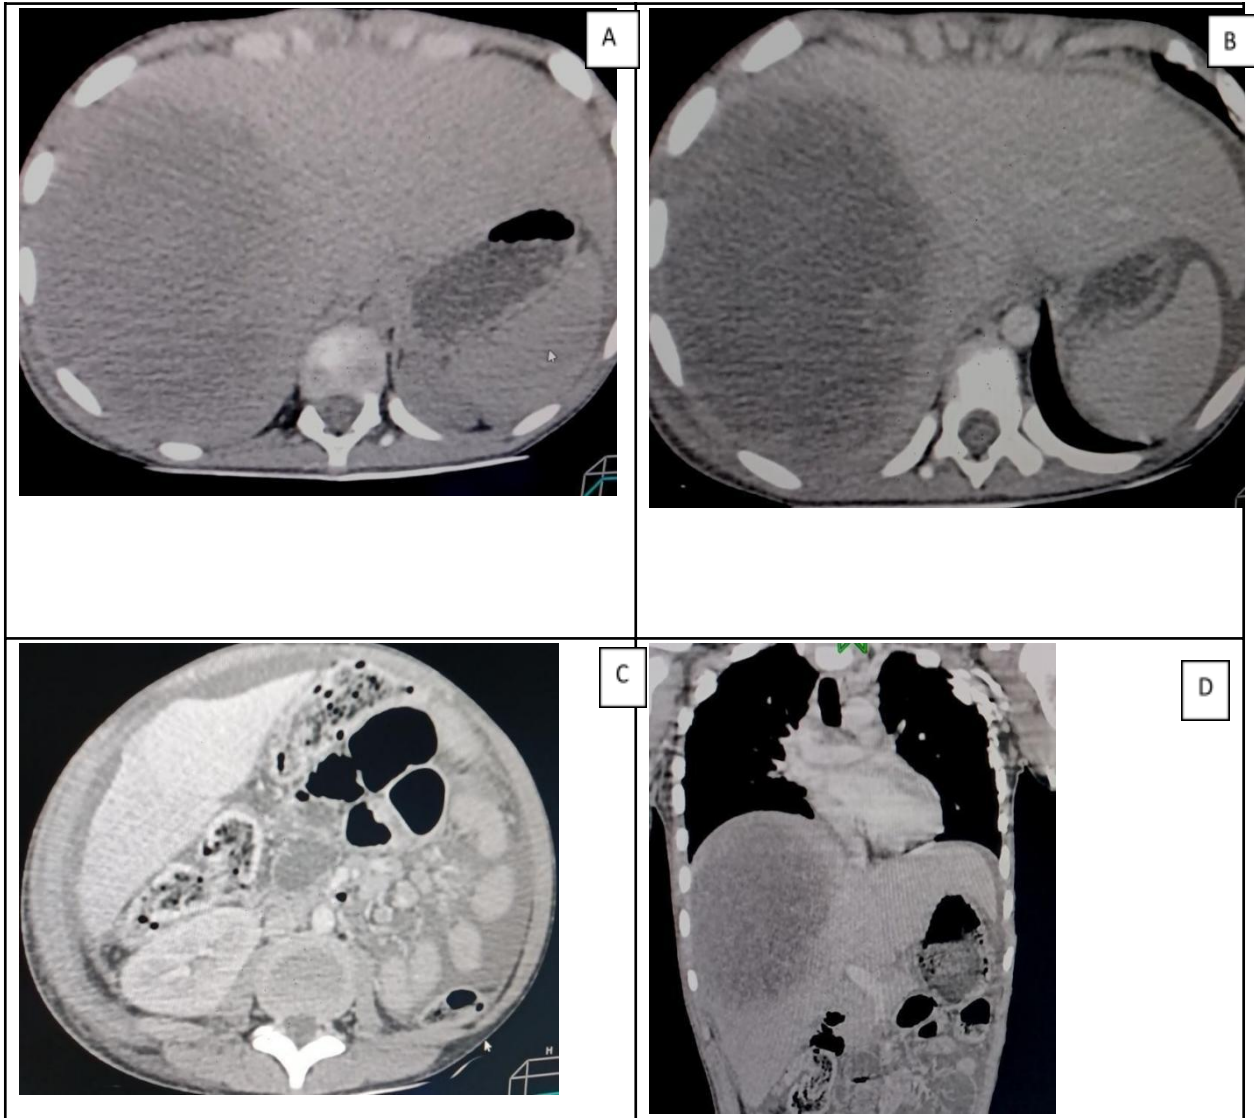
A)Axial plain CT abdomen B &D) axial & coronal contrast CT abdomen showingrim enhancing hypodense lesion in right lobe of liver.
